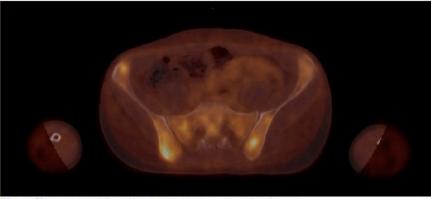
Transaxial fused FDG PET-CT image in pelvic bones
